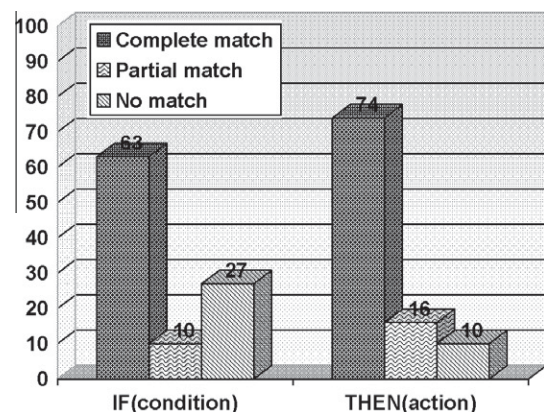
Content coverage of SNOMED CT based on concepts extracted from IF part or THEN part of the logical statements coming from six commonly used guidelines ($n = 133$).
